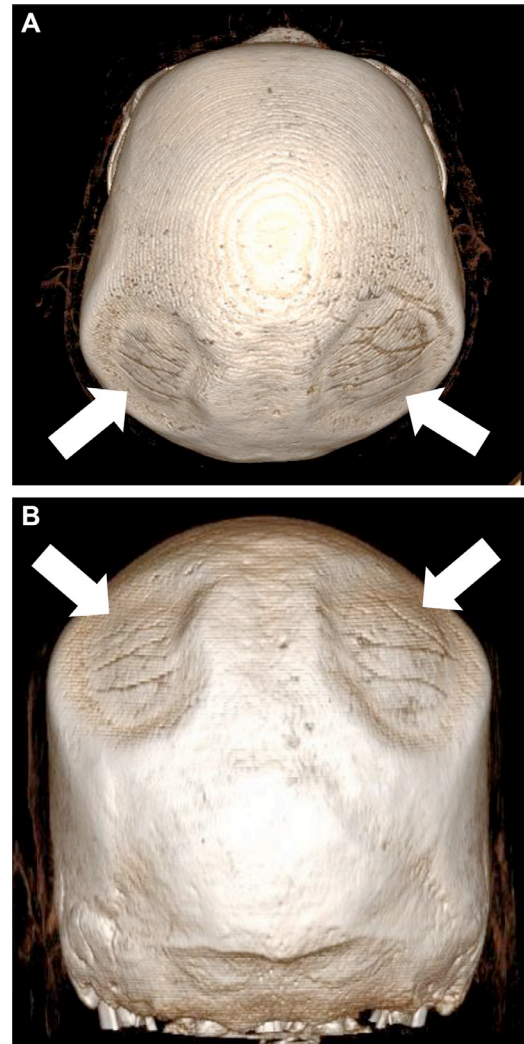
Three-dimensional volume-rendered CT reconstructions of the skull from a superior (A) and a posterior (B) perspective. These images clearly depict the bilateral parietal bone concavities (white arrows) on the vertex of the skull. The defects are symmetric and located between the sagittal suture (midline) and the parietal eminences laterally. The smooth margins and absence of any full-thickness perforation are evident on these reconstructions, consistent with biparietal osteodystrophy.
